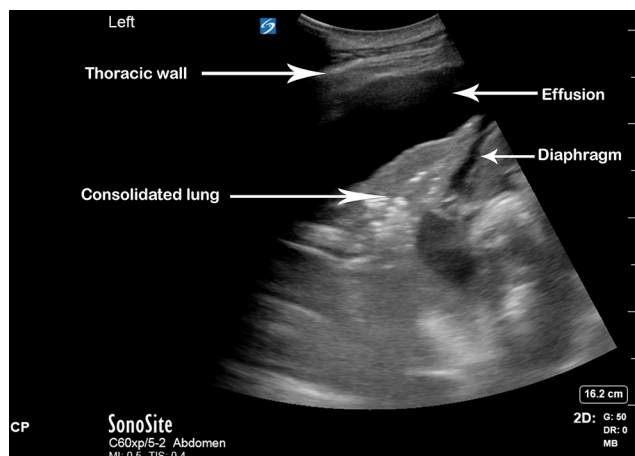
Lung ultrasonography scan showing lung consolidation and parapneumonic effusion secondary to basal pneumonia (curved array).
